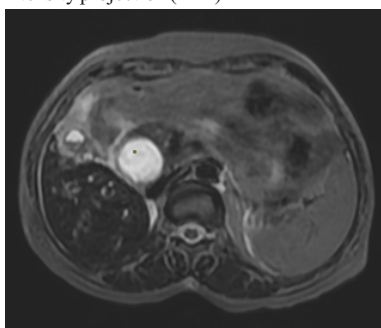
Axial MRI T2 sequence shows focal cystic dilatation of proximal common bile duct with choledocholithiasis - Type Ib choledochal cyst.
